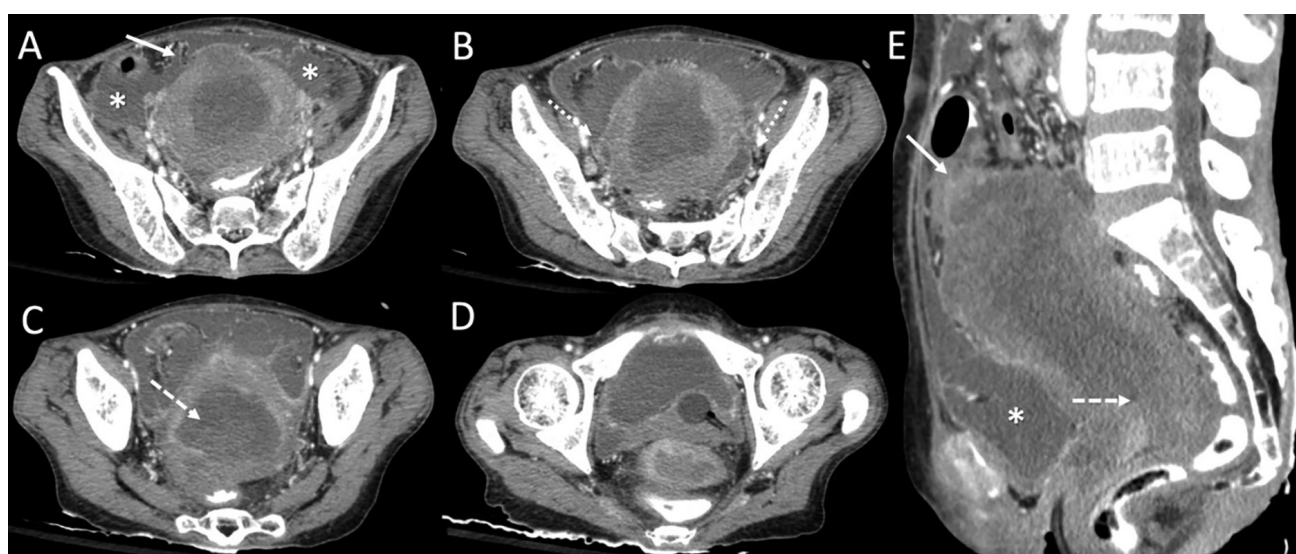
Contrast-enhanced computed tomography (CECT) pelvis in axial projections craniocaudally (A-D) and sagittal reformatted projection (E) showing gross ascites (*) and an enlarged uterus with heterogenous fluid-filled expansion of the endometrial cavity and cervical canal indicative of pyometra.
